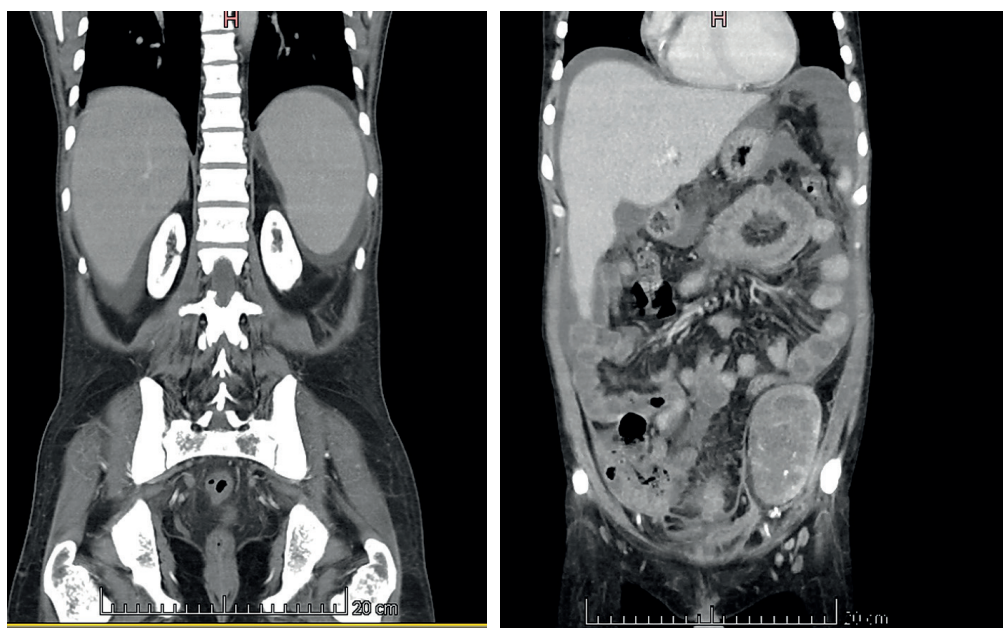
(A) Coronal CT of native kidneys showing extensive calcification. (B) Coronal CT through the transplant in the left lower quadrant. The graft is severely hydronephrotic and a few calcifications are seen in the kidney, but no significant calcium deposits are noted in the skeletal muscles.
